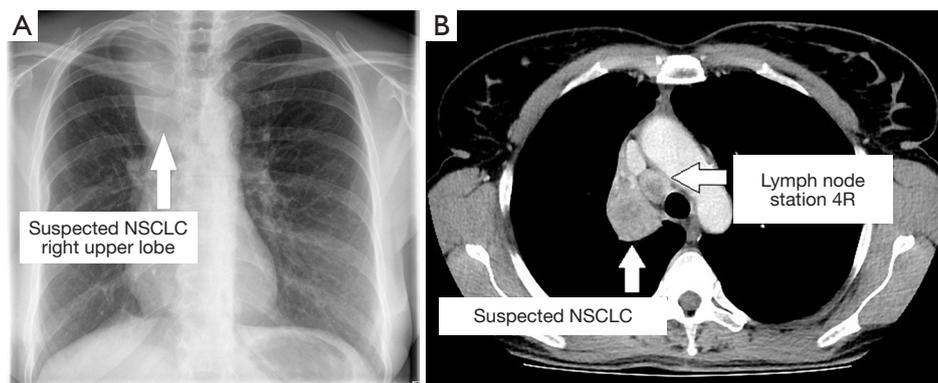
Both preoperative chest X-ray (A) and axial CT-scan with IV contrast (soft tissue window, B) implicates a NSCLC of the right upper lobe with tumor-positive lymph node station 4R (provisional TNM classification: T2 N2 Mx). NSCLC, non-small cell lung cancer; CT, computed tomography; IV, intravenous; TNM, tumor node metastasis.
